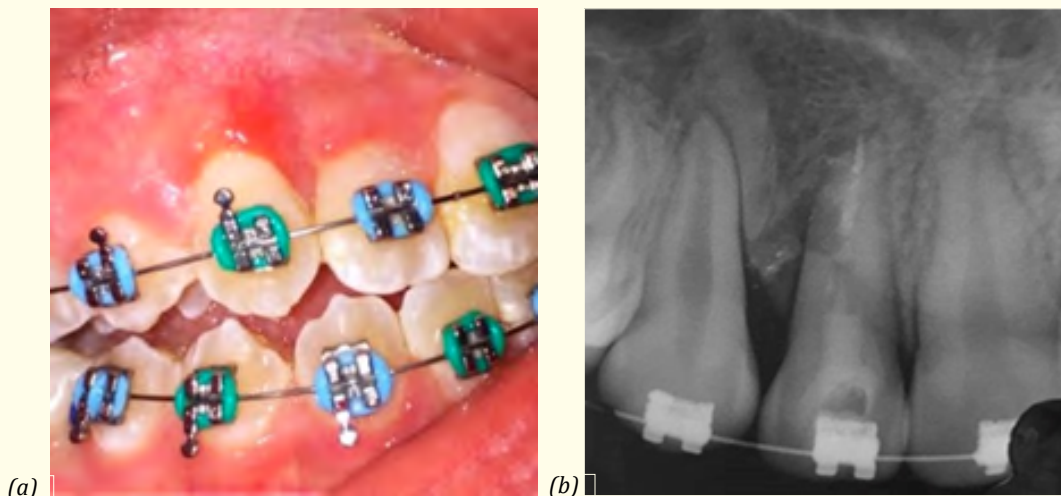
(a) Clinical control and (b) radiographic after 2 years of surgical therapy.
